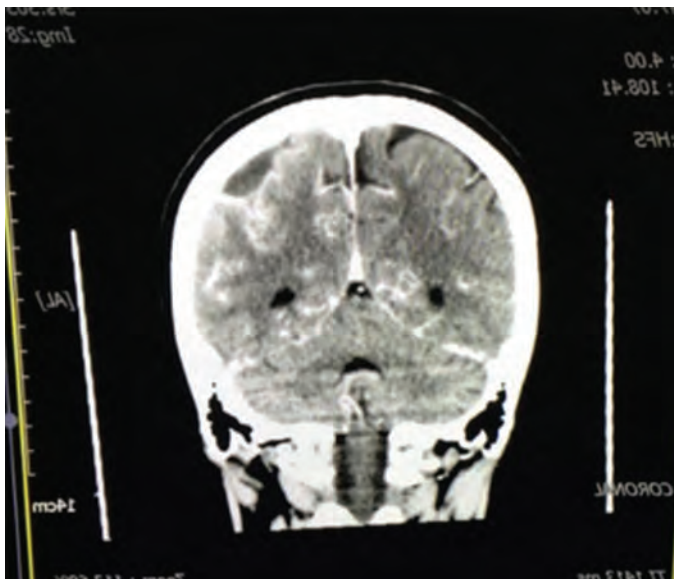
Non-contrast CT in early postoperative period
